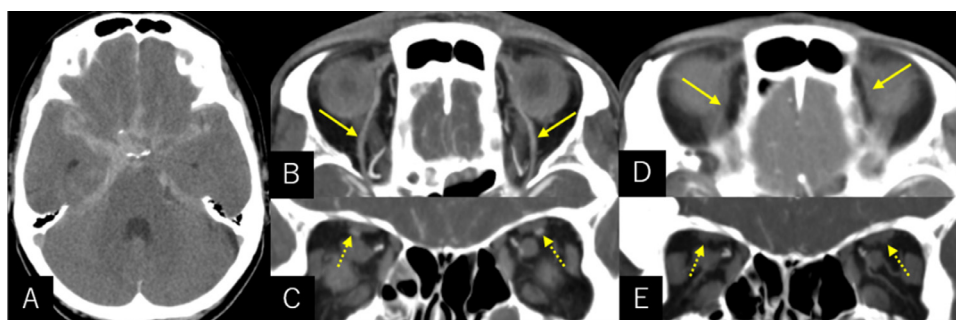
Axial computed tomography (CT) scan of a 72-year-old woman showing diffuse subarachnoid hemorrhage (A). Postcontrast axial (B, D) and coronal (C, E) CT images at presentation (B, C) and on POD 68 (D, E), respectively, showing a remarkable reduction in the diameters of both superior ophthalmic veins on the axial (B and D, arrow) and coronal (C and E, dashed arrow) images.
